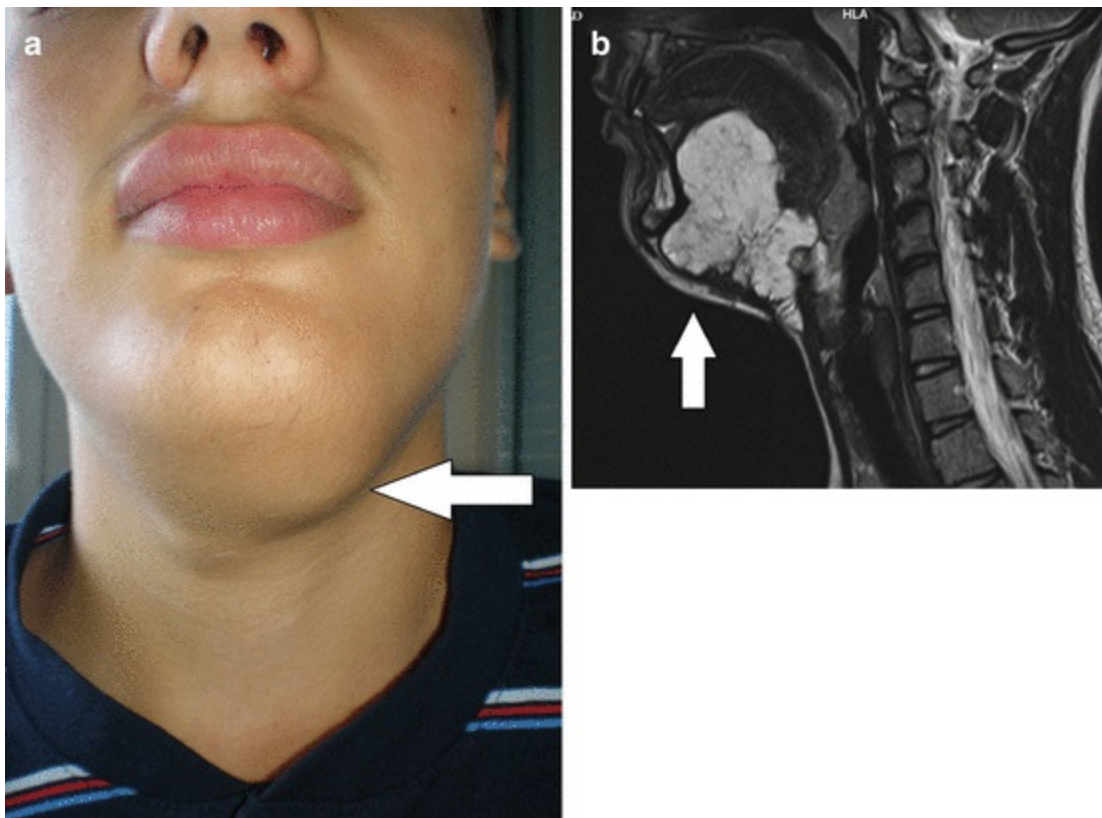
Venous malformation of the sublingual region: (a) submandibular lesion; (b) magnetic resonance imaging of the lesion
